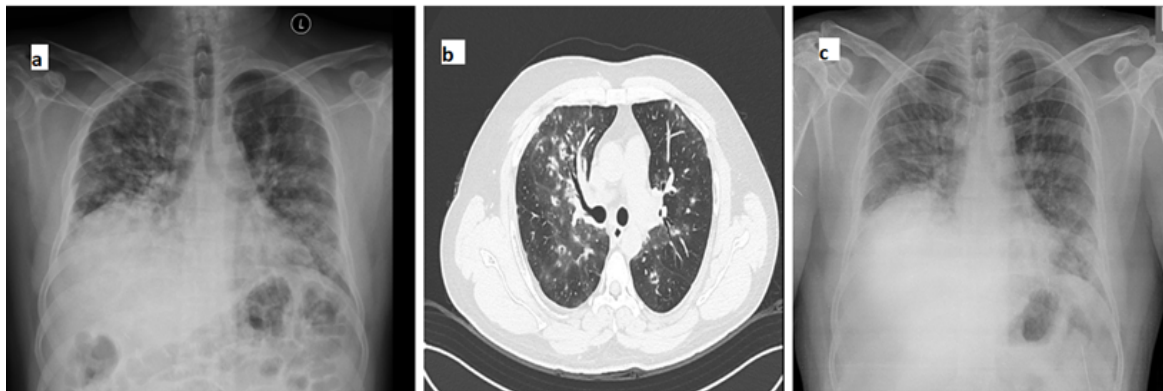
Case 2 a: Chest X-ray showing multiple bilateral irregular nodular opacities with left lower zone patchy consolidation and elevated right hemidiaphragm; b: Computed tomography thorax showing multifocal patchy air space opacities in the form of conglomerate nodules in which few nodules were cavitating throughout bilateral lung fields; c: Post Treatment Chest X-Ray resolution.
